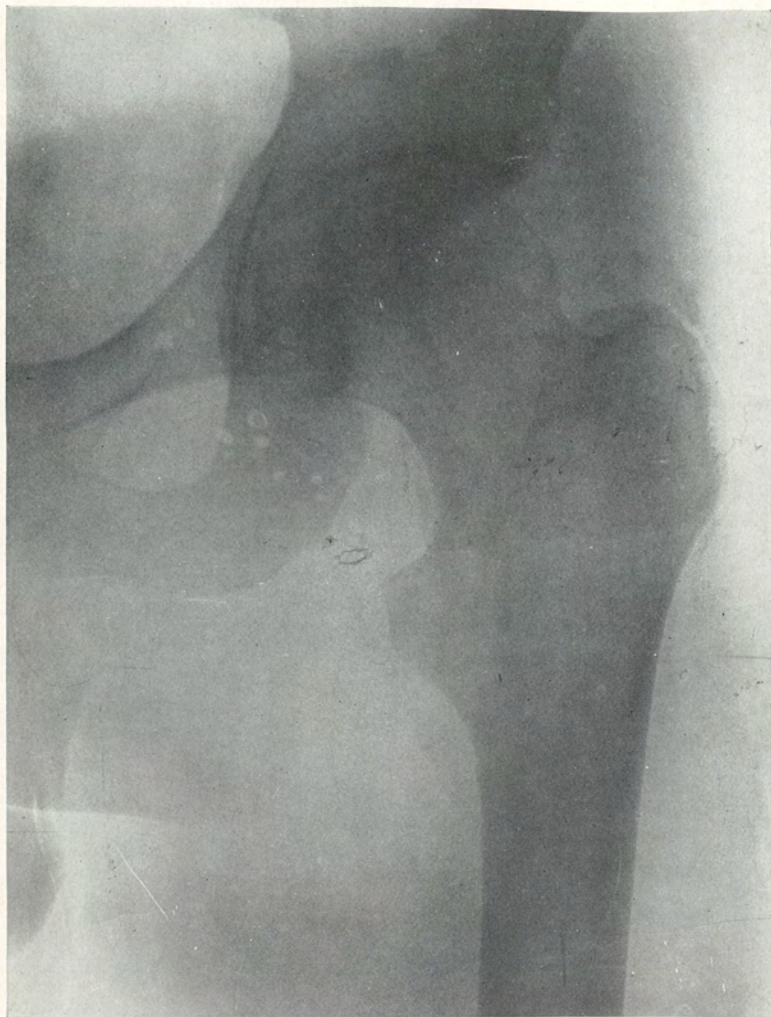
Case IX. X-ray No. 257*a*. Showing femoral head in position after reduction.
